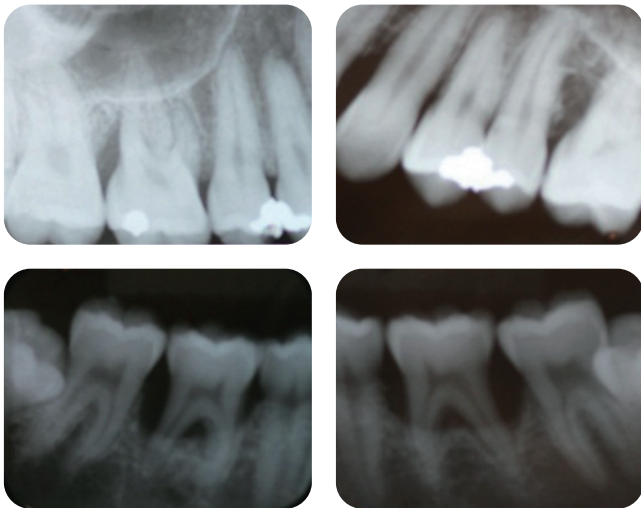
Periapical radiographs demonstrating the intrabony defects surrounding all four molars and the relatively normal premolars and second molars.
